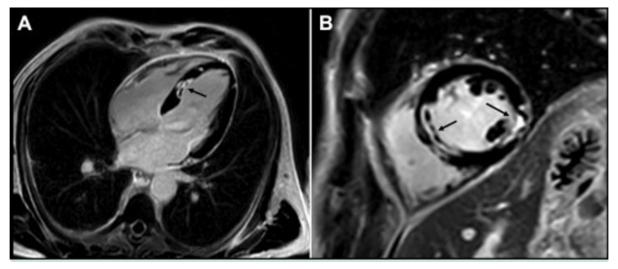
Cardiac MRI A) Four chamber view and B) Short axis view demonstrating late gadolinium enhancement in the septal and inferolateral wall.
